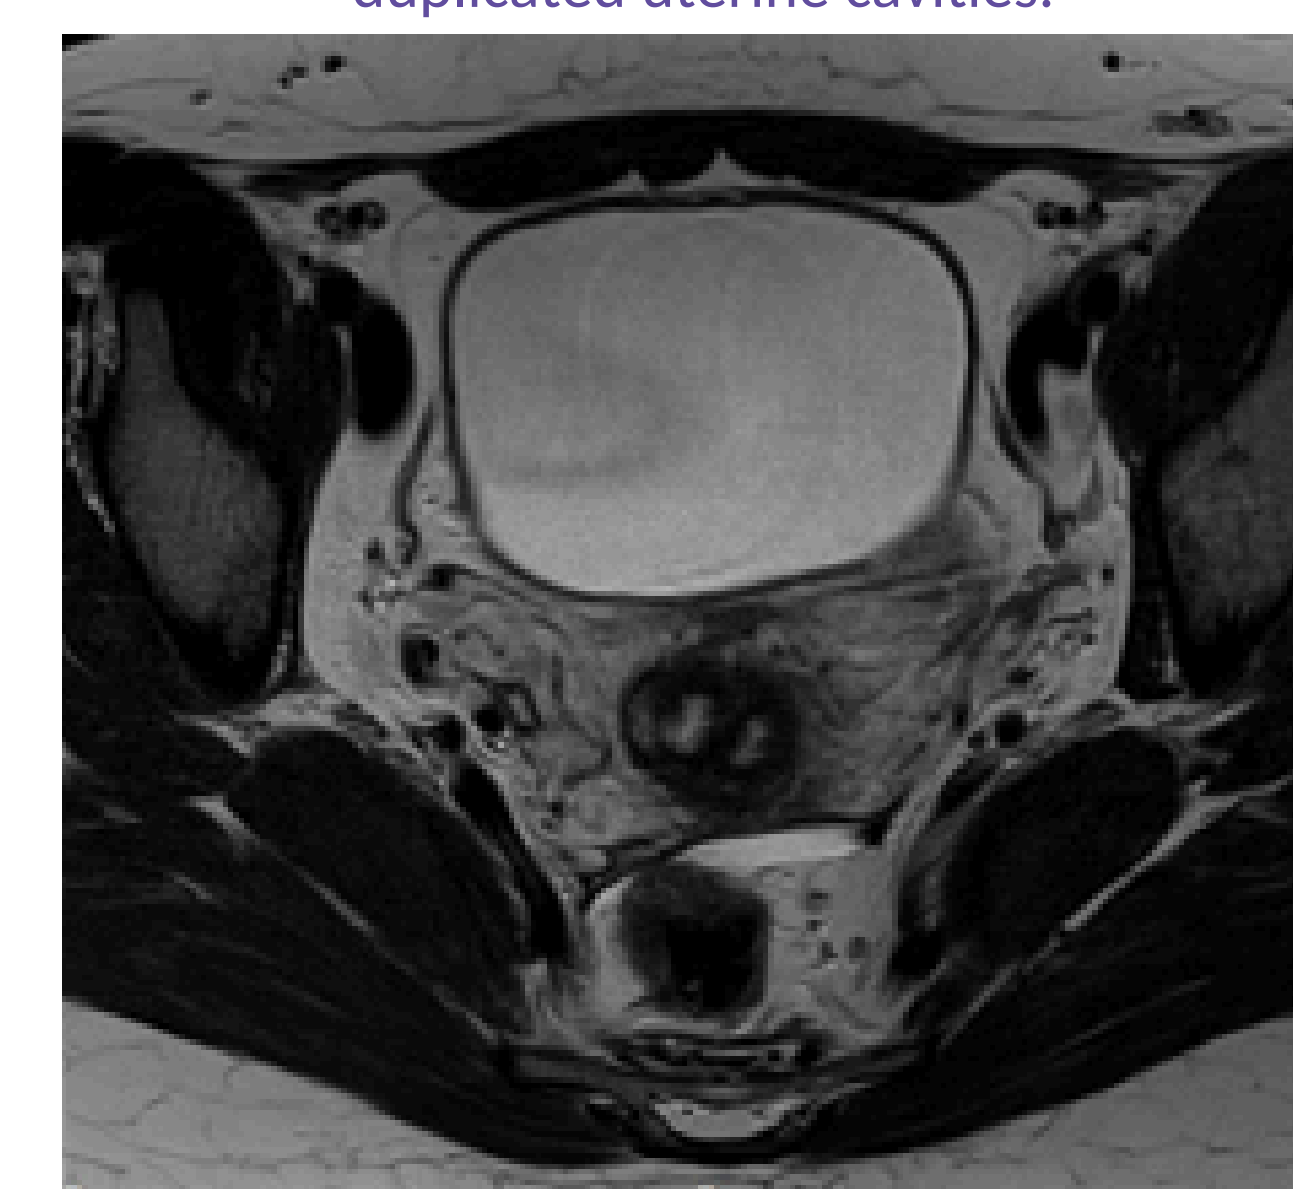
MRI Pelvis. T2 Axial demonstrating duplication of cervix.
